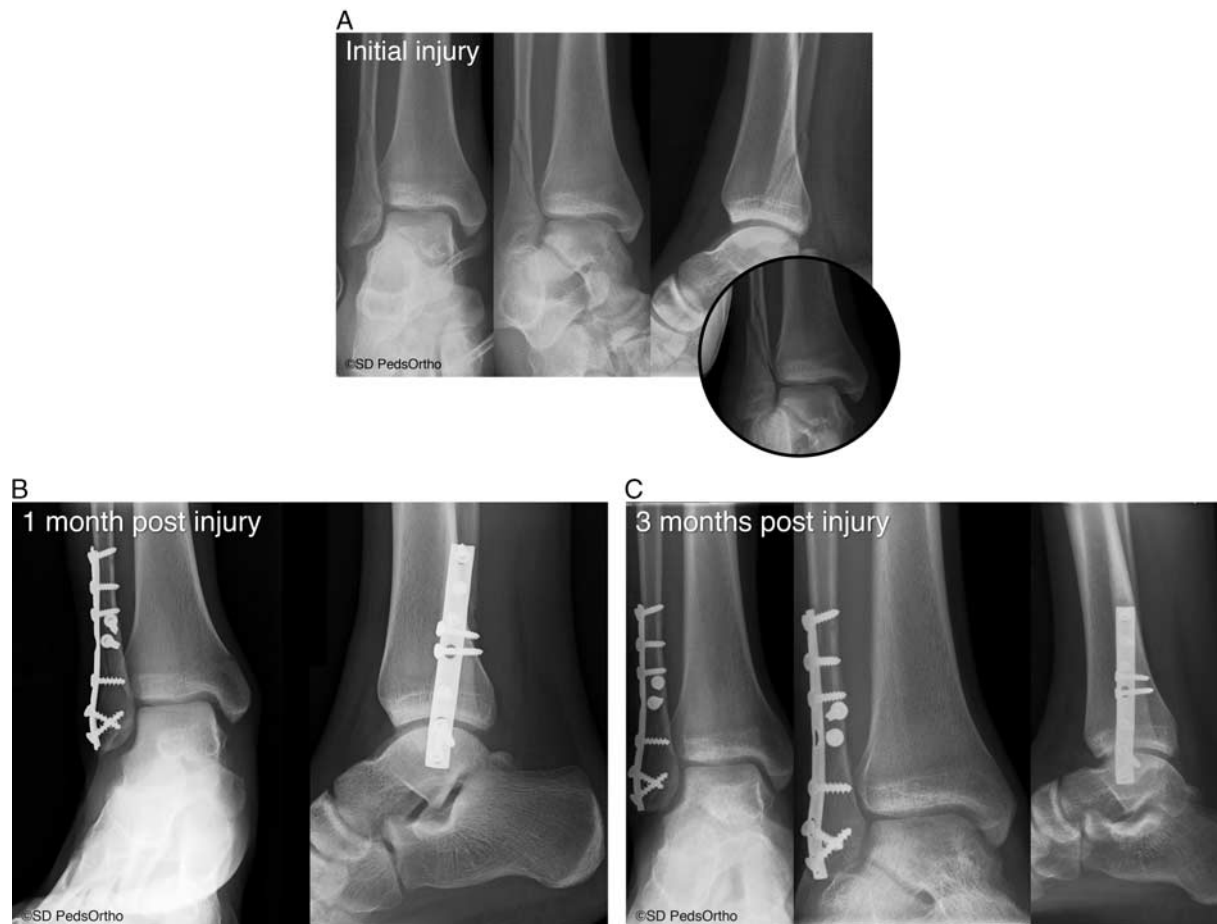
A–C, Radiographs of a 17-year-old male who sustained a supination external rotation stage IV injury with disruption of the deltoid ligament demonstrated on stress views (inset image) (A) while riding a motorcycle. He underwent open reduction internal fixation and was placed in a short-leg non-weight-bearing cast for 3.5 weeks followed by a short-leg walking cast for 4 weeks. At 4-year follow-up, the patient scored 100% on the Foot and Ankle Ability Measure Sports subscale.
